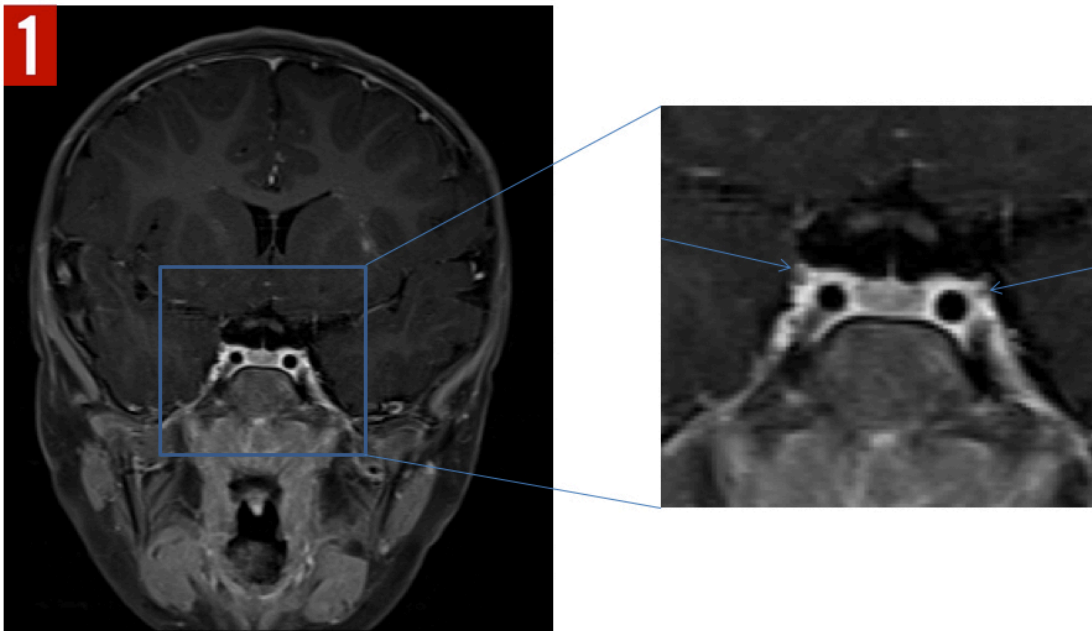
T1-weighted fat-saturated post-gadolinium coronal MRI. Arrows indicate the bilateral branches of the oculomotor nerve within the cavernous sinus. Enhancement within the left internal capsule is related to an incidental developmental venous anomaly. Courtesy of Thomas Graham West, MD, Wake Forest Baptist Medical Center.
